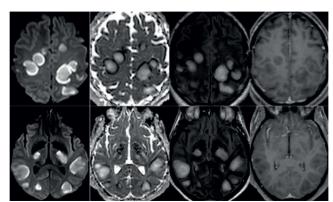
54-year old man with pathological wakefulness after sedation. Non-confluent multifocal white matter hyperintense lesions on FLAIR and diffusion, with variable enhancement. Multiple nodular hyperintense Diffusion and FLAIR subcortical and corticospinal tracts lesions. Elevated ADC corresponds to vasogenic edema and a ring of reduced ADC corresponds to cytotoxic edema (C, D). Mild enhancement is detected (G, H). Figure reproduced with permission from Kremer S et al. (2020) copyright 2020 RSNA. doi.org/10.1148/radiol.2020202222
